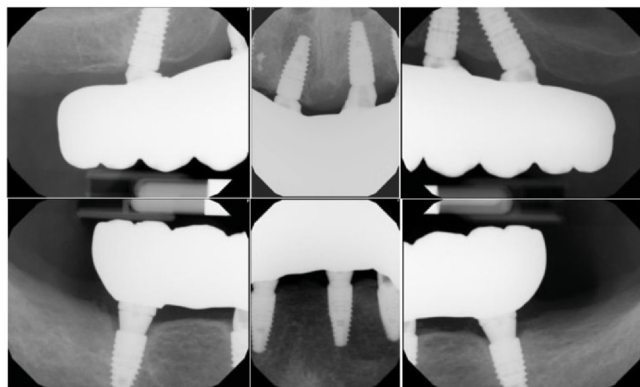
Periapical radiographs immediately after insertion of maxillary and mandibular definitive prostheses.
